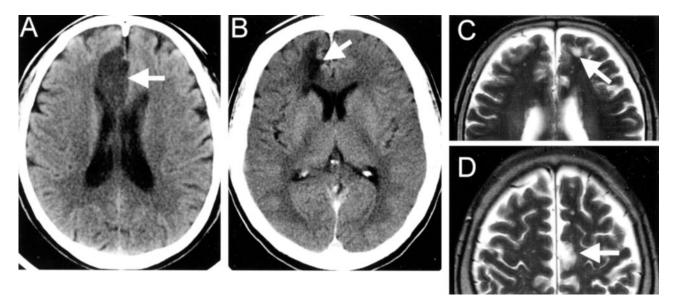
CT scans and MR images show infarction in patients presenting with cerebral ischemia.
